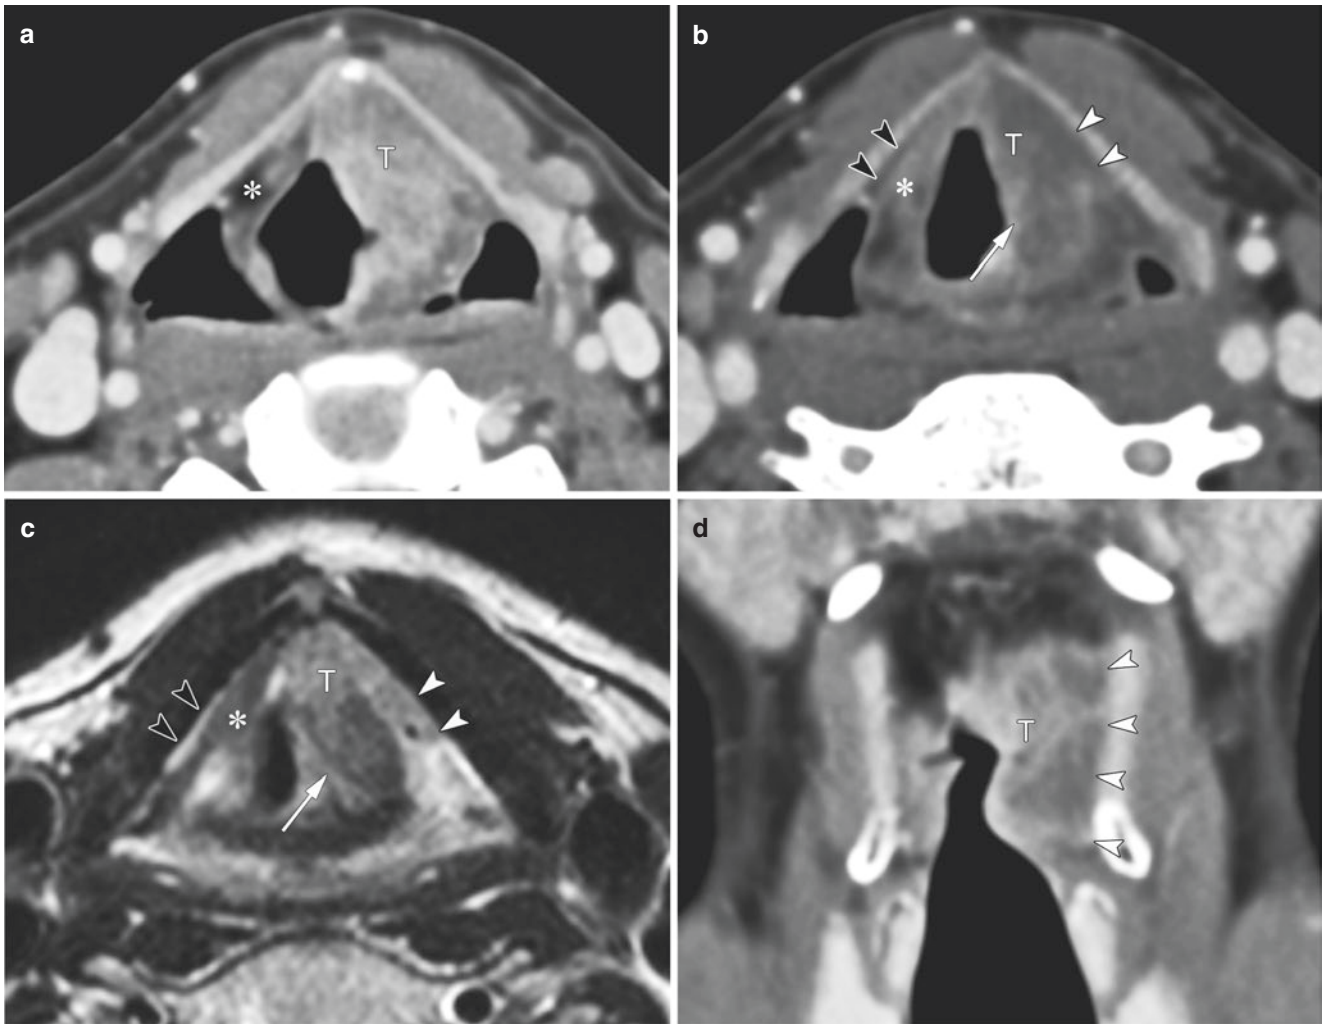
Supraglottic cancer with transglottic spread through the paraglottic space. Axial contrast-enhanced CT images (a) demonstrate the tumor (T) of the left infrahyoid epiglottis, with infiltration of the preepiglottic space (the asterisk is normal right preepiglottic space). Axial image, more inferiorly (b), shows downward tumor extension along with the preepiglottic space and paraglottic space (white arrowheads), as well as posterolateral growth into the thyroarytenoid muscle (arrow). T2-weighted images (c) (corresponding the same slice of b)
